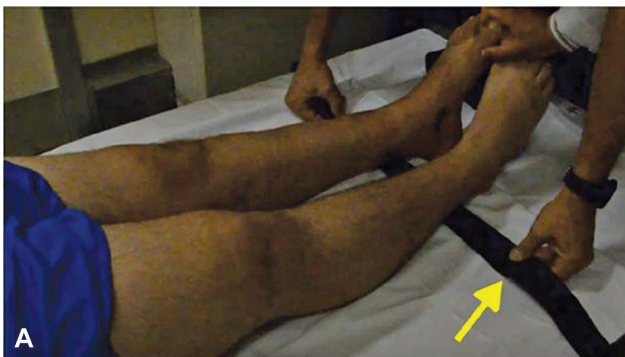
The patient is placed supine on the radiographic table and asked to extend the knees. The ankles and thighs of both limbs are placed in contact. Following this, a Velcro belt (yellow arrow) is used at the supramalleolar level to keep the medial malleoli in contact.
